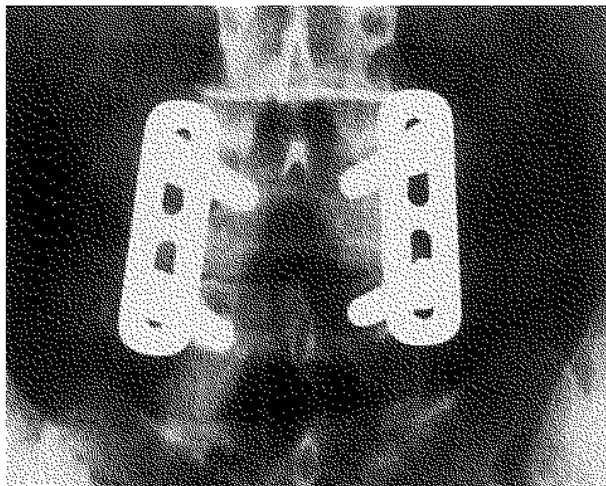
AP radiograph of a single level dorsal fusion (L₄-L₅), fixed by the "Variable Screw Placement Spinal Fixation System". The spondylodesis is rigidly fixed by a bilateral system of transpedicular screws and plates.
